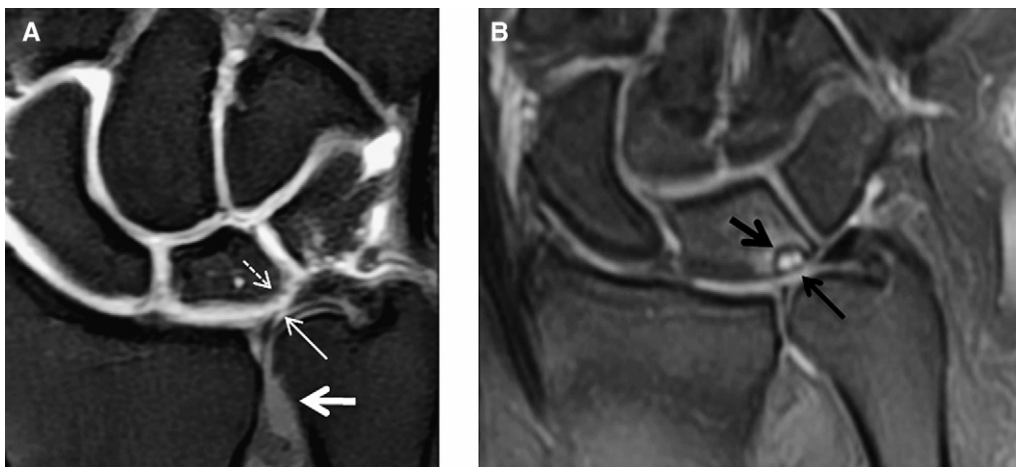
Palmer class 2B and 2C lesions. Coronal T1-weighted fat-saturated magnetic resonance (MR) arthrogram (A) and coronal proton density (PD) fat-saturated (B) MR images, demonstrating Palmer class 2 lesions. The Palmer class 2B lesion (A) consists of triangular fibrocartilage proper (TFC) thinning (thin white arrow) and lunate chondromalacia (dotted white arrow). Note the absence of gadolinium in the distal radioulnar joint (thick white arrow). The class 2C lesion in a different patient (B) consists of TFC perforation (thin black arrow) and lunate chondromalacia. Note the subchondral cyst formation and oedema within the lunate (thick black arrow).
